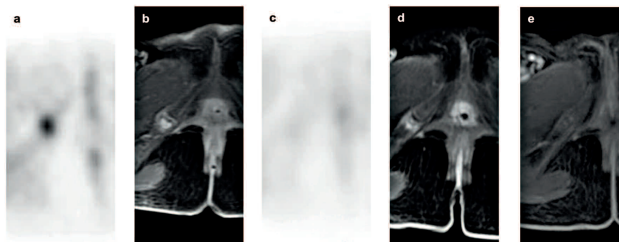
Time course of the changes of ^{18}F -FDG PET and contrast-enhanced MRI findings. Initial ^{18}F -FDG PET (a) shows high ^{18}F -FDG uptake on the right IPS. MRI, 4 days after the initial ^{18}F -FDG PET (b) shows the same with contrast enhancement. ^{18}F -FDG uptake in the IPS has disappeared on follow-up ^{18}F -FDG PET, 6 weeks after the initial ^{18}F -FDG PET (c). However, weaker contrast enhancement still remains on the follow-up MRI 4 months after the initial ^{18}F -FDG PET (d). Seven months after the initial ^{18}F -FDG PET, contrast enhancement in MRI has finally disappeared (e).
